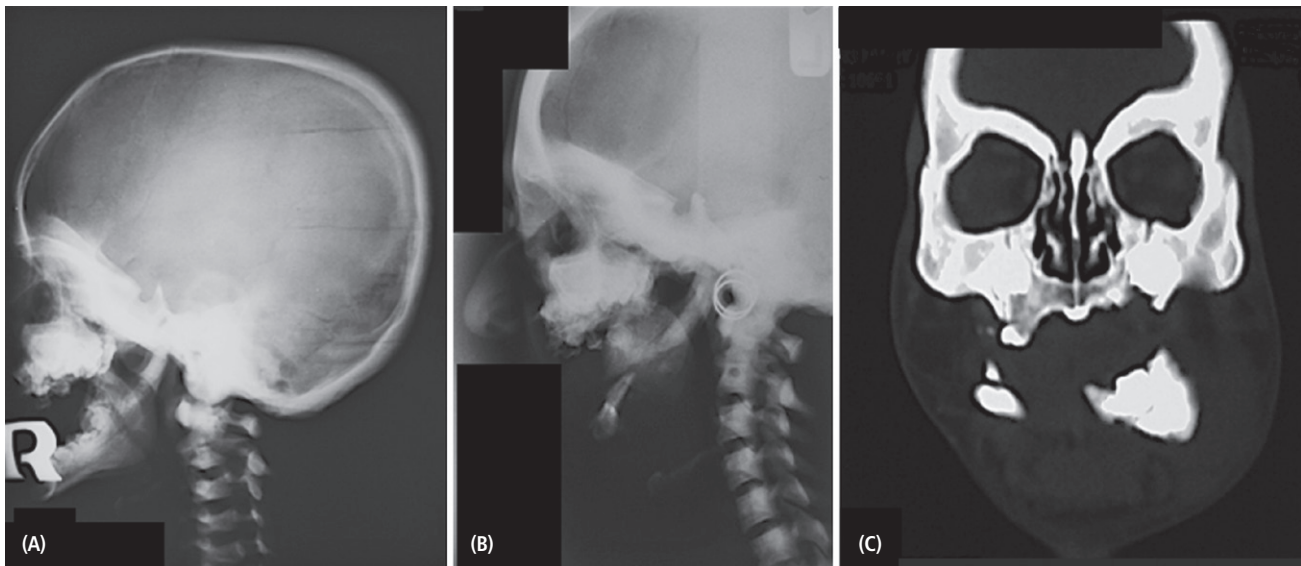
Lateral cephalograms taken at age 15 (A) and 25 (B) years, respectively. The cranial base and atlas bone are dense. (C) The cranial vault and posterior clinoid process are much thicker at age 25 years. CT shows obliteration of maxillary sinuses and the mandible after partial mandibulectomy.
